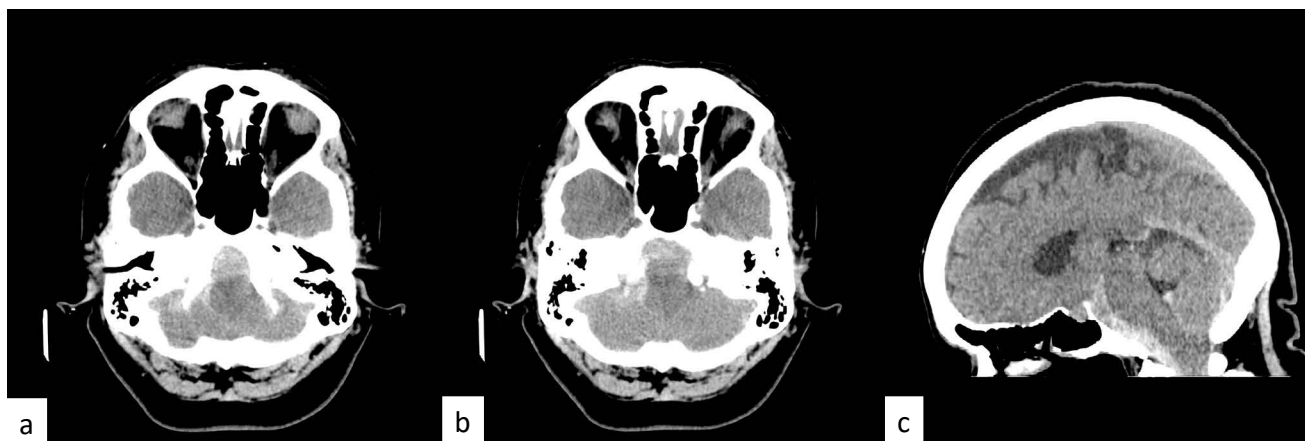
a), b) and c) CT scan demonstrated subarachnoid hemorrhage predominantly in the prebulbar and prepontine cisterns and in the IV ventricle. A grade IV in the Fisher scale.
